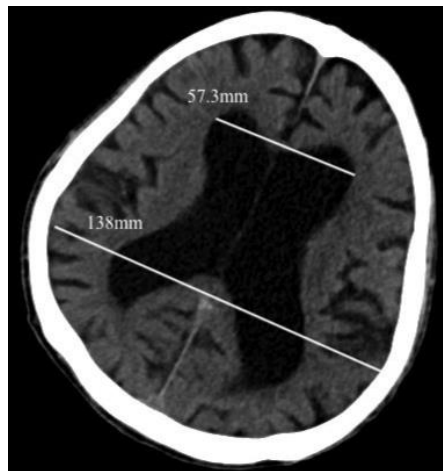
Plain computed tomography of the brain showing an Evans' Ratio >0.3
